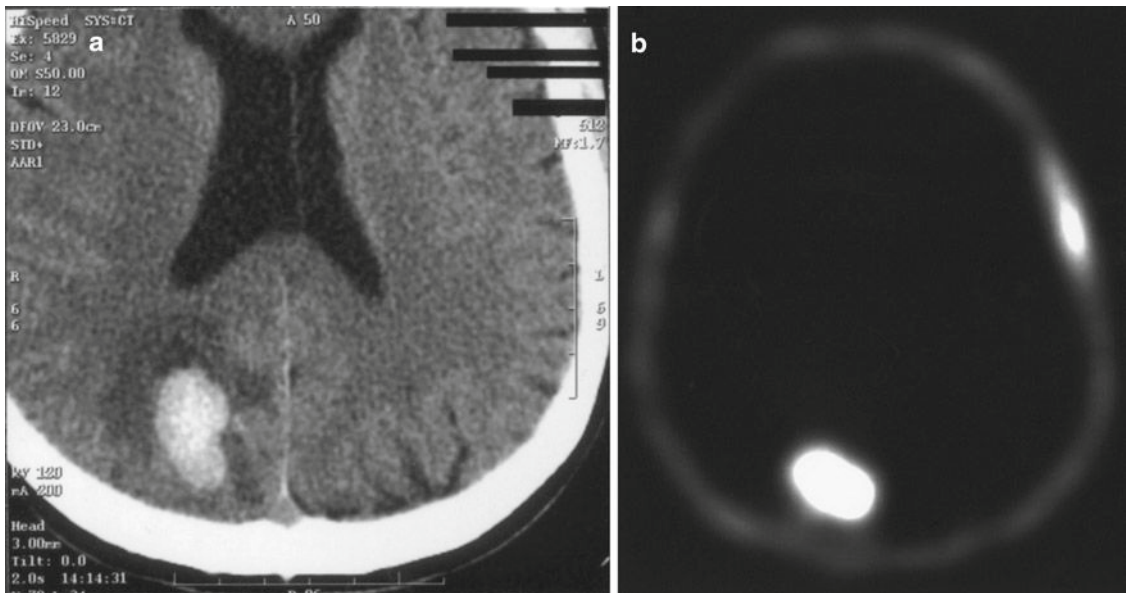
(a) Emergency CT scan obtained after sudden onset of drowsiness and left hemiparesis, showing a brain hematoma atypically located in the right parieto-occipital region in a 56 year-old male patient without vascular risk factors. The lesion is surrounded by moderate edema. (b) On  $^{99m}\text{Tc}$ -MIBI SPECT, obtained 24 h after CT scan, the lesion shows very high MIBI uptake. After MR imaging, that was not conclusive nor for malignant etiology or for benign hematoma, the patient underwent surgery and pathological analysis of the excised lesion revealed hemorrhagic glioblastoma multiforme
